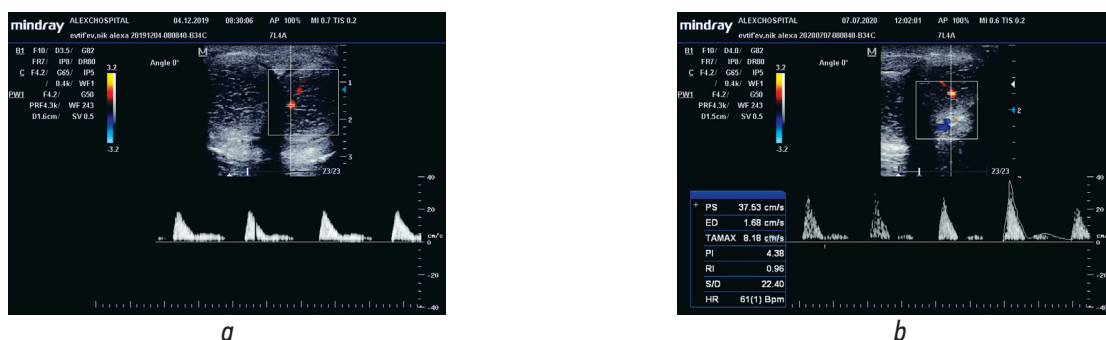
Doppler ultrasound of the vessels of the penis of patient B., 59 years old, BPH and arteriovenogenic erectile dysfunction. *a* – Before the operation: in the tumescence phase V_{max} 21.3 cm/s, *RI* 0.79, Valsalva’s test is positive, the dorsal cavernous vein did not collapse, the blood flow through it was 23 ml/min; IIEF-5 before surgery 13 points; *b* – after laser enucleation of the prostate (HoLEP): in the tumescence phase V_{max} 37.5 cm / s, *RI* 0.96; IIEF-5 after surgery 21 points
